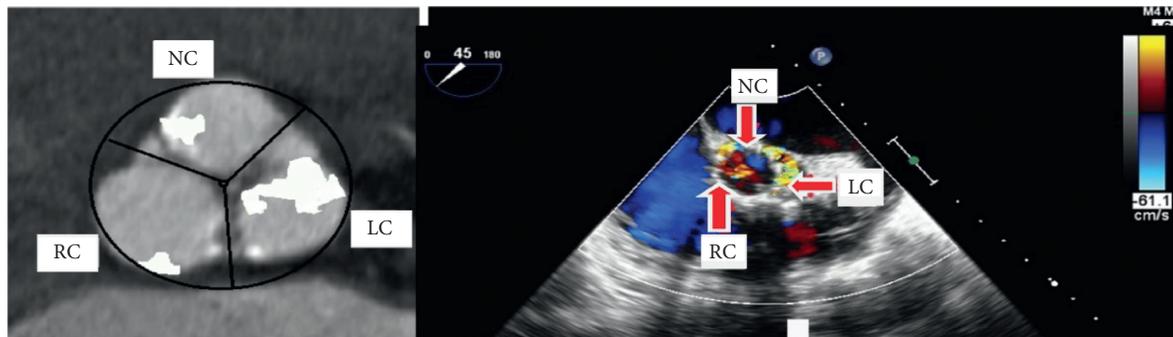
Example showing paravalvular leak jet location on echocardiography matching with the location of AVC on MSCT (image of the MSCT is rotated to be easily compared with the corresponding view of echocardiography). LC: left coronary cusp; RC: right coronary cusp; NC: noncoronary cusp.
